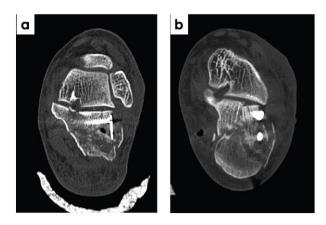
Postoperative computed tomography scan of posterior facet reduction. a. anatomical reduction of posterior facet, b. poor reduction of the posterior facet.
